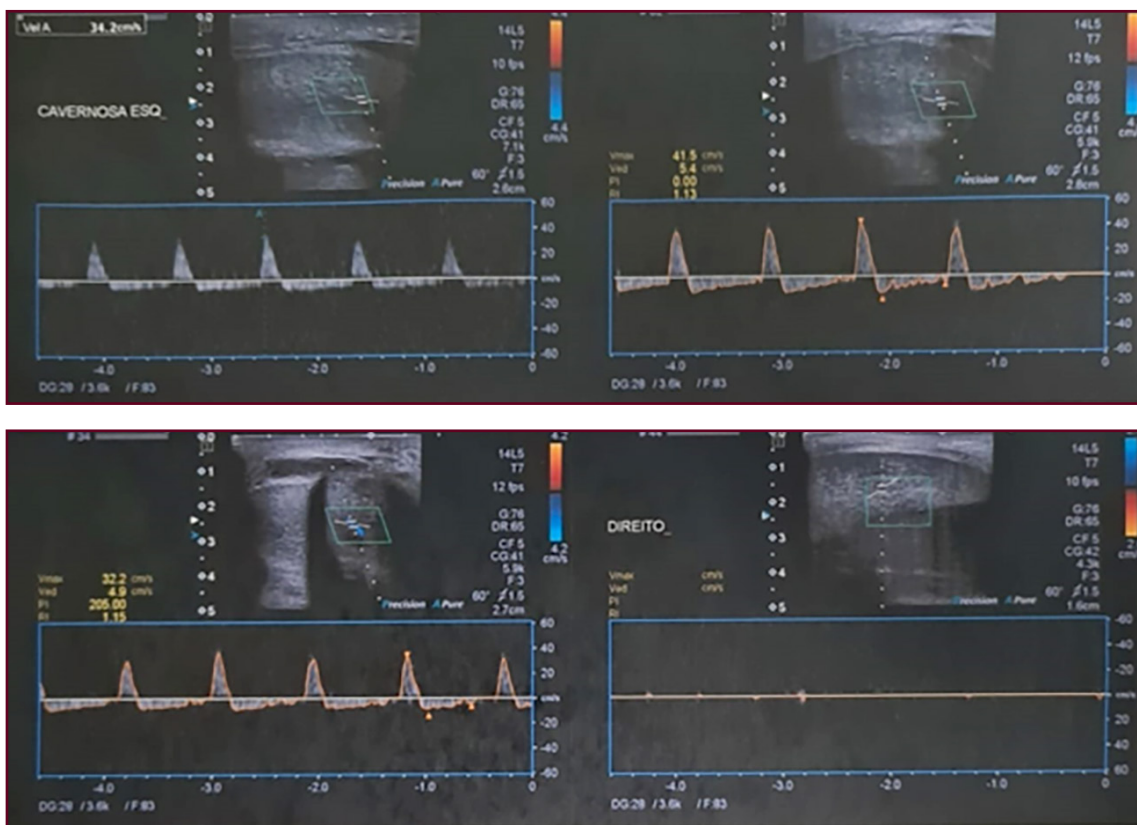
Ultrassonografia peniana com Doppler.
